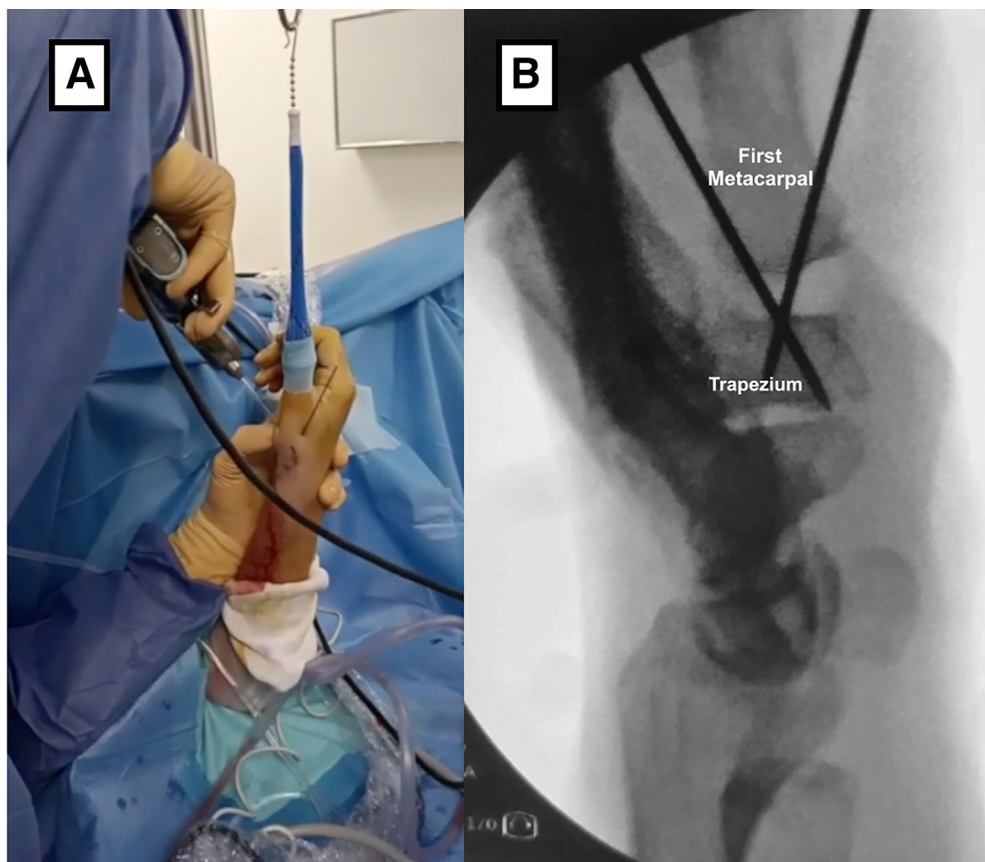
Bone fixation method allowing distraction of the trapeziometacarpal joint. (A) Intraoperative view of the placement of the 1-mm wires without releasing traction. The wires are inserted from distal (metacarpal) to proximal (trapezium), with less risk of nerve damage. To avoid discomfort, they will not be buried under the skin. (B) Intraoperative radiograph with the wires in place but after removal of the distraction. Note the intra-articular space maintained by the pins.
